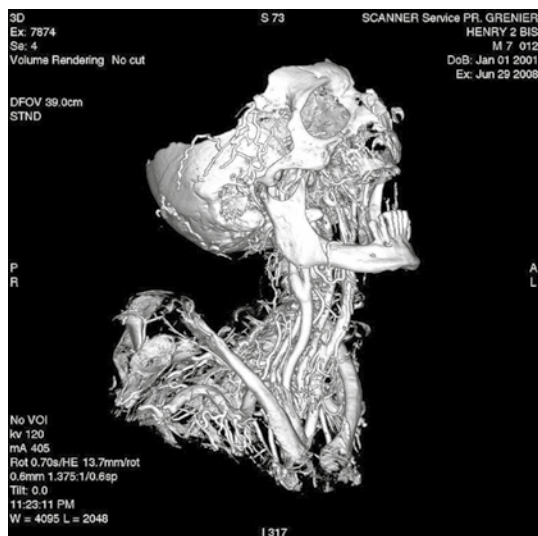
CT scan aspect of the human anatomical preparation (bone density) showing the skeleton, dentition and artery filling
